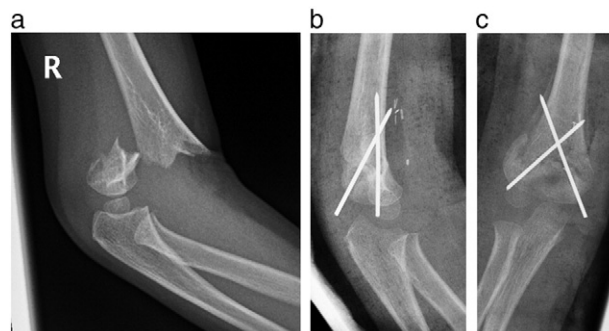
a: initial X-ray after trauma; b, c: postoperative X-ray in 2 planes after revision operation.
